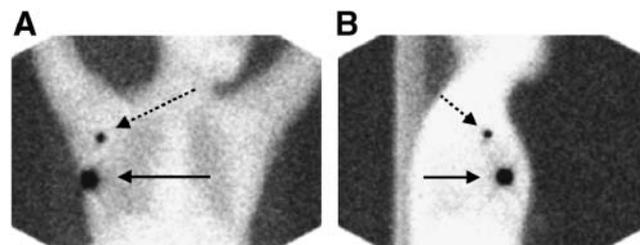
Anterior (A) and right lateral (B) transmission images obtained 30 min after lymphoscintigraphic injection in left breast show injection site (solid arrow) and focal uptake (dashed arrow) in sentinel node in right axilla.
